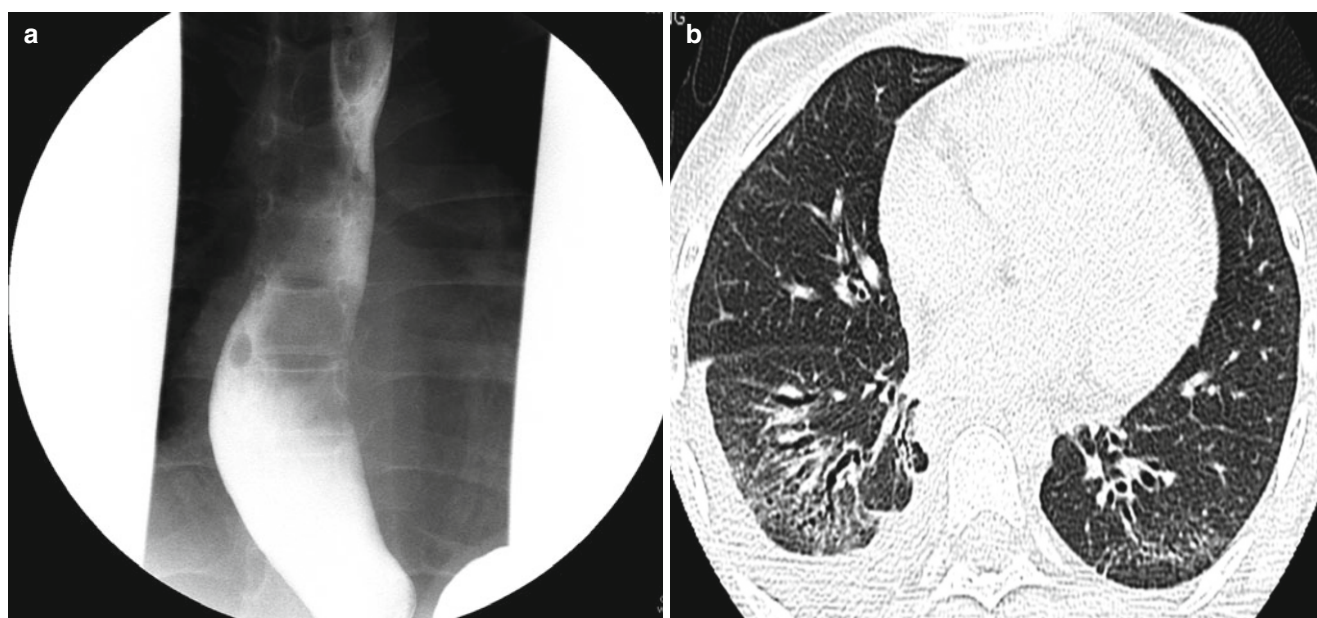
Systemic sclerosis in a 13-year-old girl. (a) Frontal fluoroscopic spot image obtained during barium swallow study shows a dilated esophagus. (b) Axial lung window CT image demonstrates
